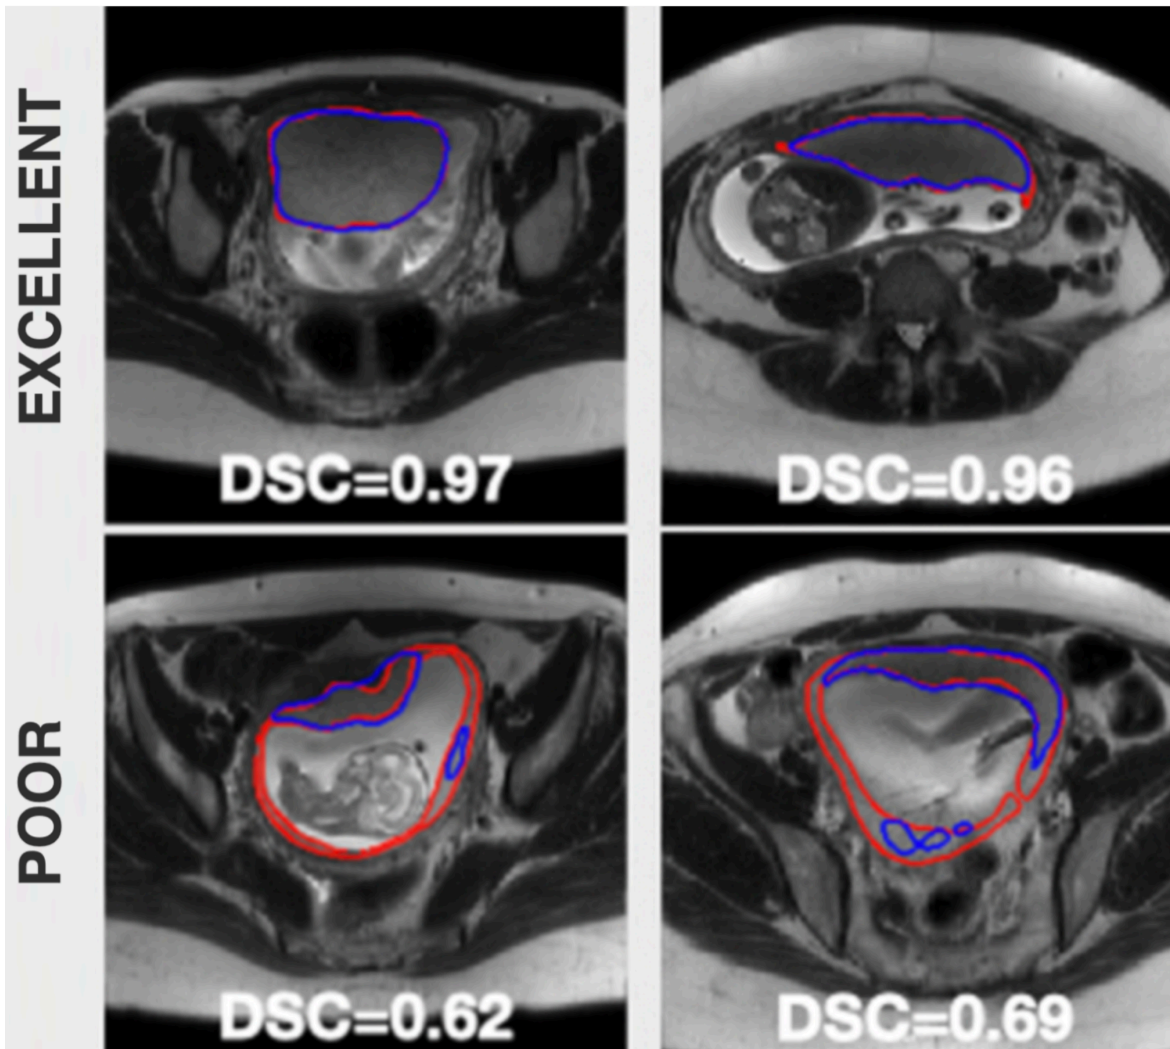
Representative examples of excellent and poor automated placental segmentation at the first MRI scan (GA between 14-18 weeks) and the second MRI scan (GA between 14-18 weeks) by the proposed method. Red and blue lines are manual and automated segmentation.
